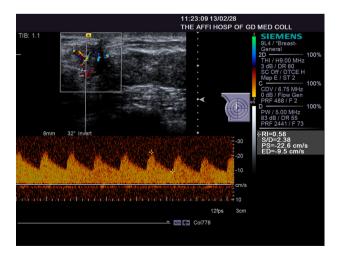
Doppler spectrum demonstrates a high velocity (22.6 cm/s) and moderate resistance index (RI) =0.58.
